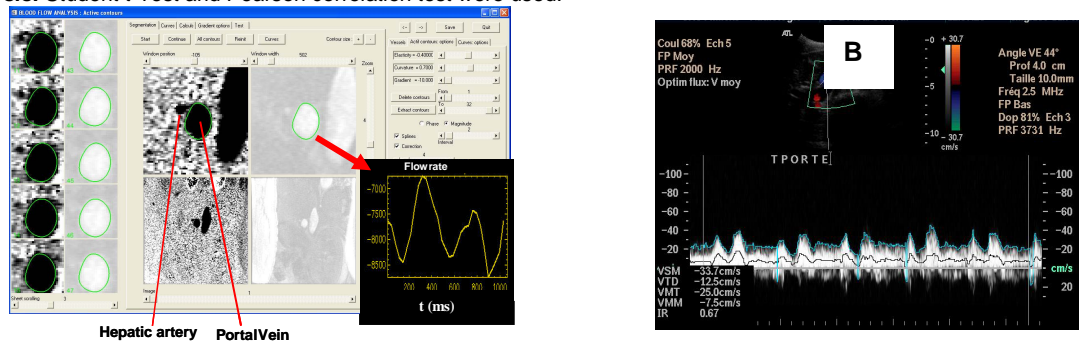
A- Segmentation software view showing: Final wall contours of a portal vein; temporal evolution curve during a cardiac cycle, the proper hepatic artery near the portal vein. B- Doppler flow waveform
